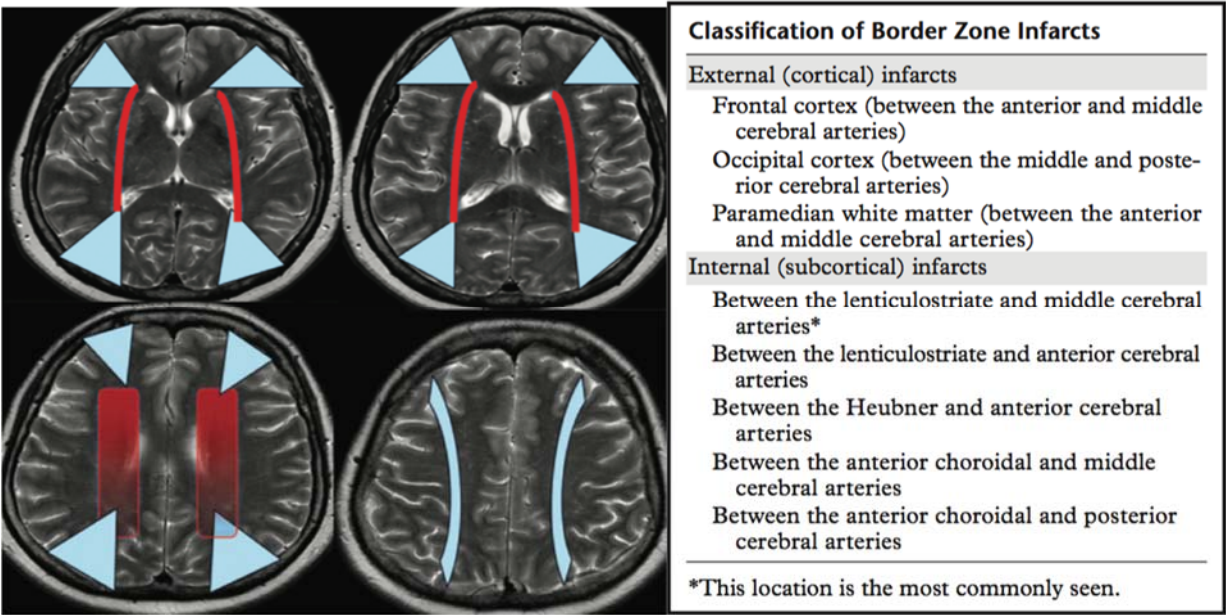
T2-weighted magnetic resonance images (MRI) of expected locations for external (blue) and internal (red) watershed infarcts from Mangla et al. (2011).
